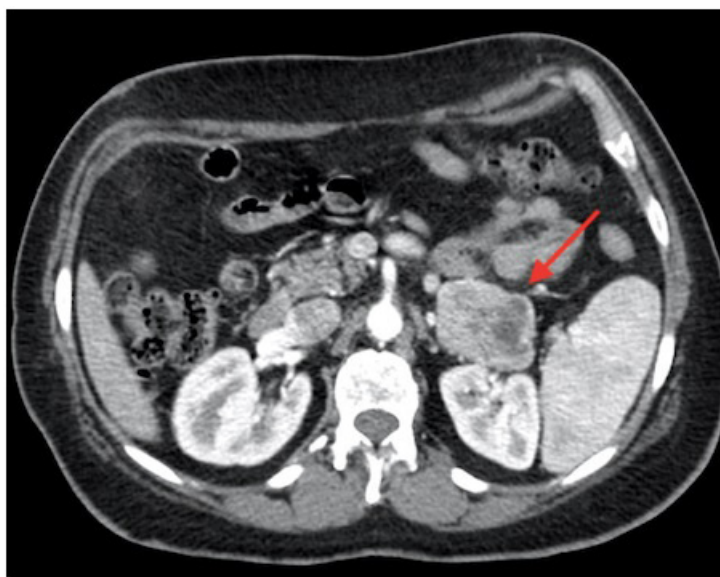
Abdominal CT: expansion of the left adrenal gland (red arrow)
